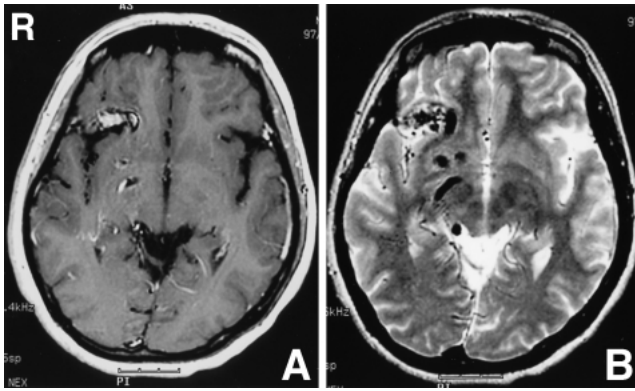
Preradiosurgical magnetic resonance images showing an arteriovenous malformation in the right frontal lobe. Gadolinium-enhanced T₁-weighted image showing enhancement of the nidus (A). T₂-weighted image showing multiple abnormal flow-void signals (B).
